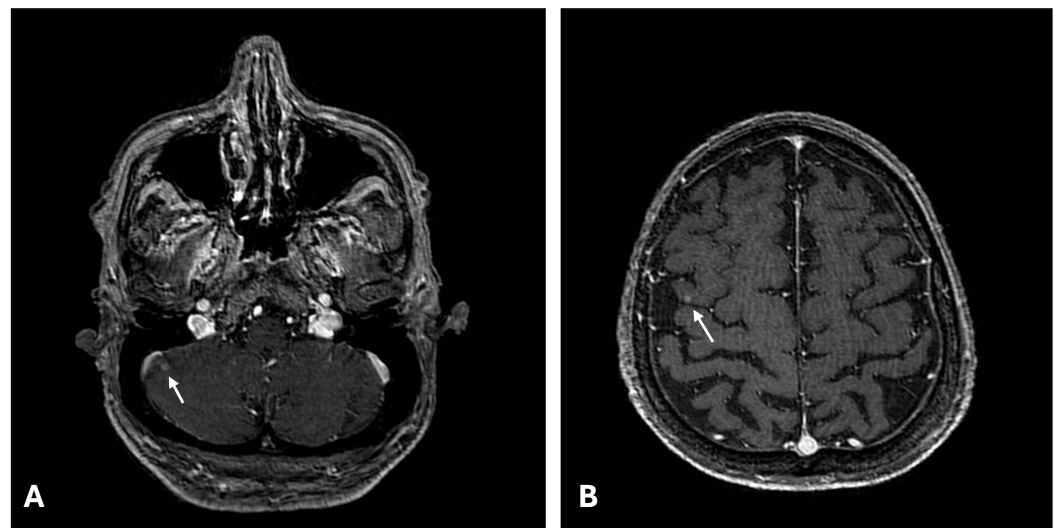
Magnetic resonance imaging. (A) Enhancing right cerebellar nodule (T1 post-GAD) (arrow). (B) Enhancing right middle frontal gyrus nodule (T1 post-GAD) (arrow).
